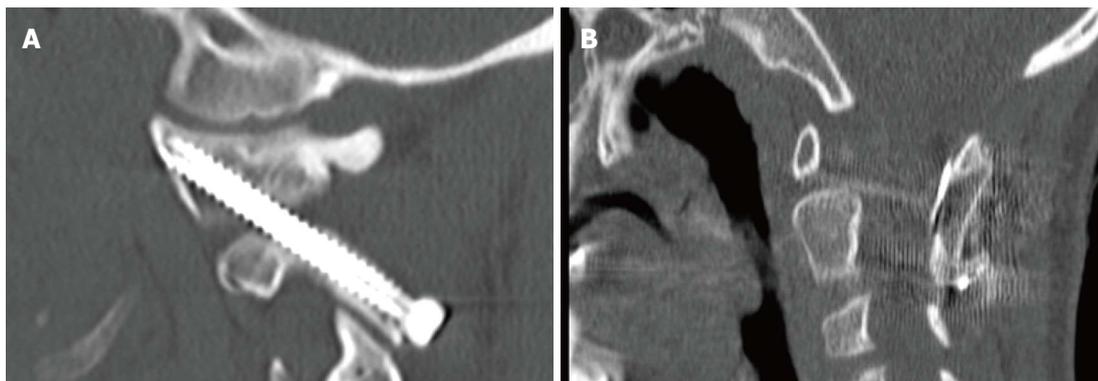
C1-C2 transarticular screws. A: Sagittal computed tomography (CT) of a fully contained and well placed transarticular screw in a 10 year-old male with Down's syndrome and os odontoideum; B: Sagittal CT cut demonstrating the placement of a structural iliac crest graft cable grafted in between C1 and C2 which supplemented transarticular screws in an 8 year-old patient with C1-C2 instability.
